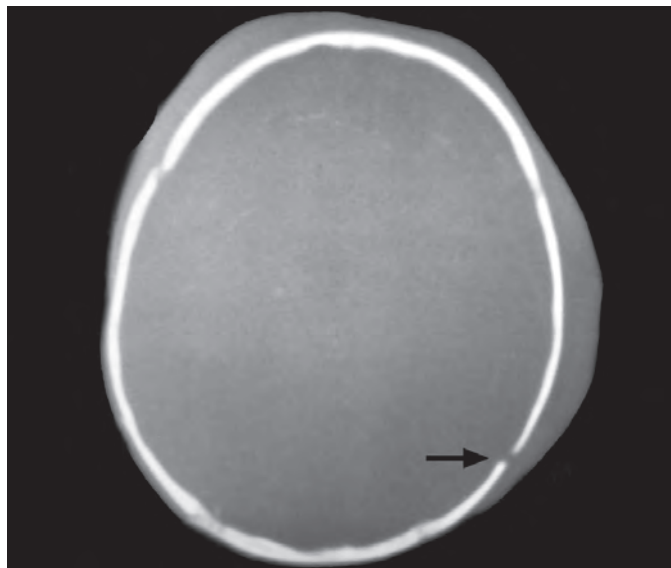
Linear fracture CT
